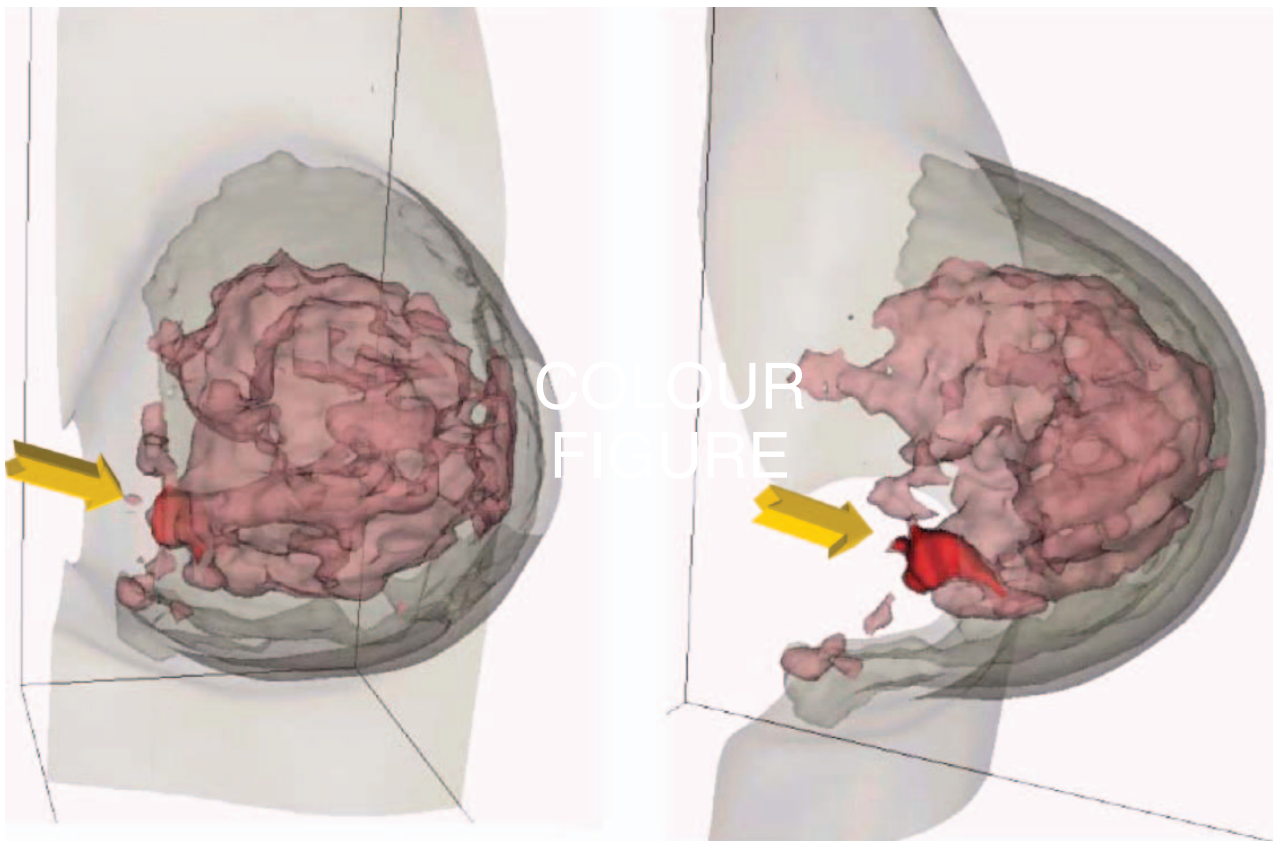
A rendering of the MRI volume (post-contrast sagittal acquisition) with the region corresponding to calcifications in the mammograms indicated by arrows. In terms of understanding the pathology, 3D morphology is much more meaningful than a slice-based representation. Additionally, models such as this may provide the surgeon with a useful location reference during excision.
